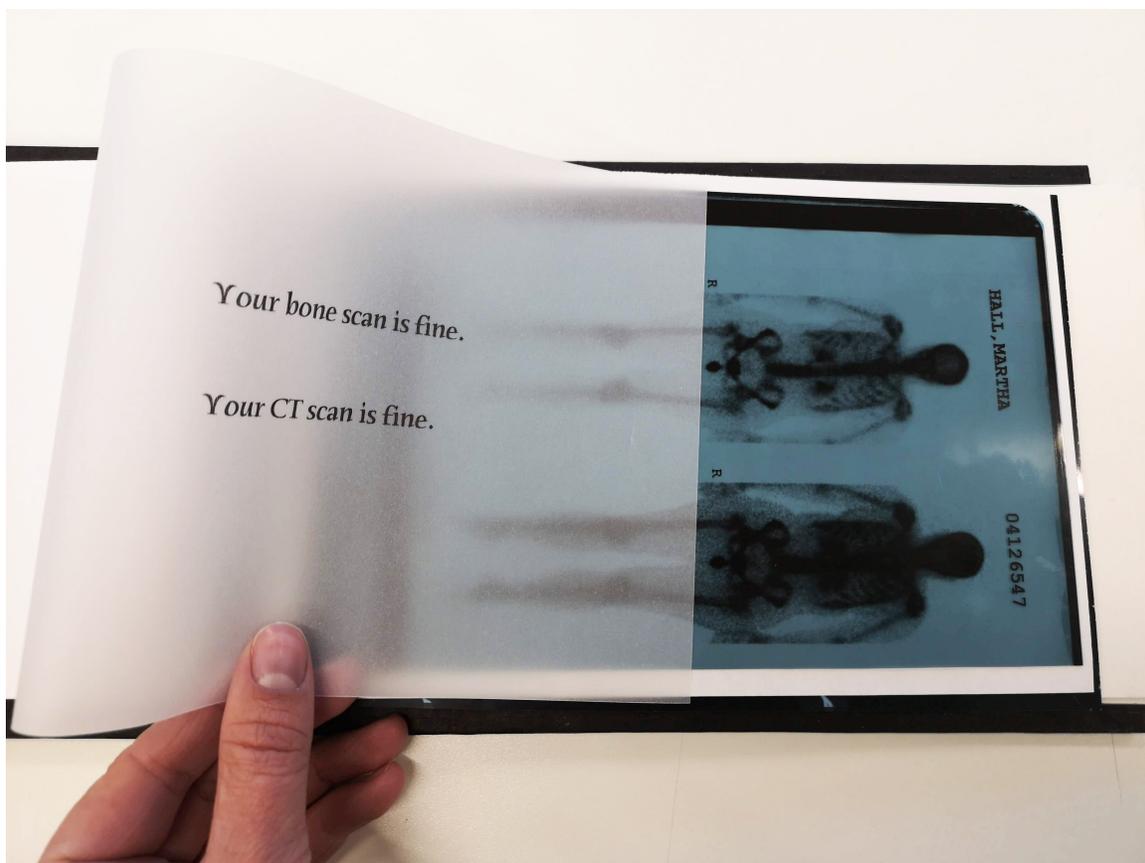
Martha Hall, *Voices: Five Doctors Speak*, 1999. This image shows a hand lifting a transparent page of a book with the text, “Your bone scan is fine. Your CT scan is fine.” Underneath are two full-body CT scans printed on blue film.
